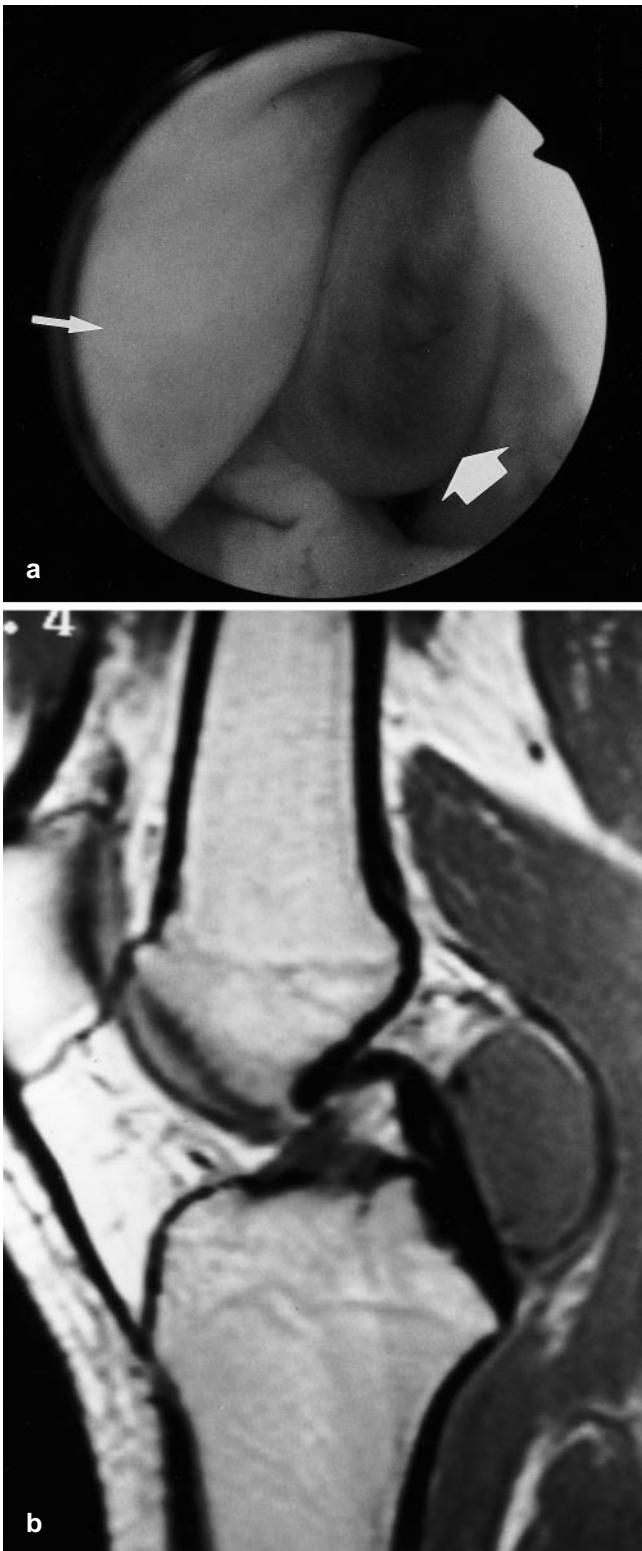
a Arthroscopy shows a small cyst (*large arrow*) between the posterior cruciate ligament (PCL) and the medial femoral condyle (*small arrow*) in the left knee. b On MRI, the cyst, which is located posterior to the PCL, is depicted as much larger than it seemed when observed by arthroscopy. T1-weighted image demonstrates a round, intermediate-signal area
